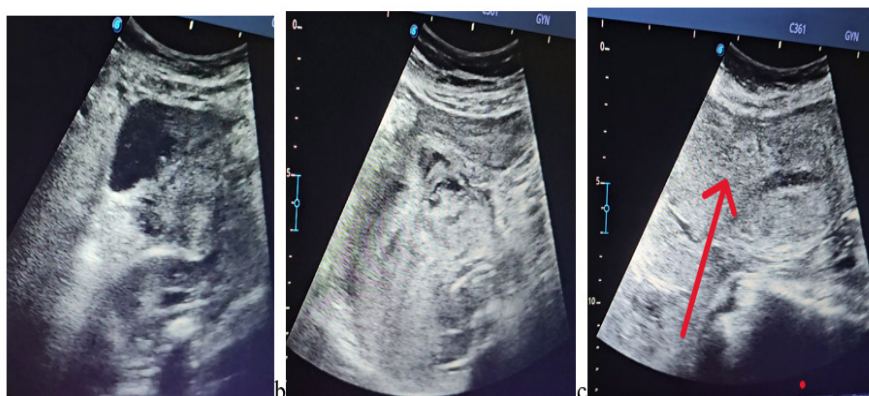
Ultrasonography results (a) showing massive intra-abdominal fluid collection (b) big intra-abdominal blood clots signifying rapid accumulation of blood (c) empty uterus with fundal defect (red arrow) continued with big clots.
